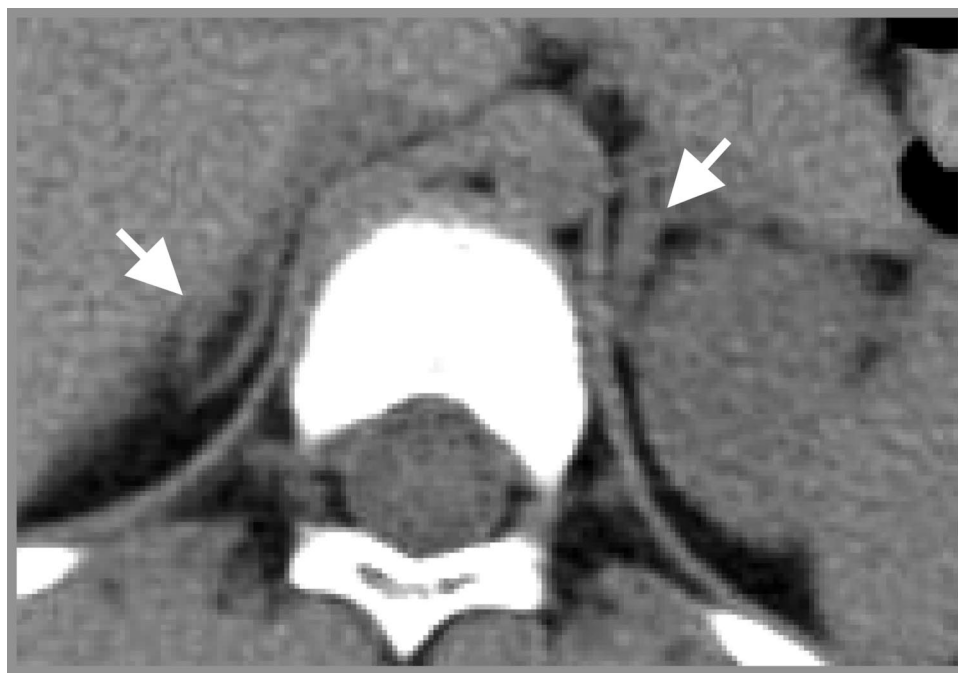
Normally shaped (but hyperplastic for age, especially *left*) adrenal glands of our patient on CT (arrows).
